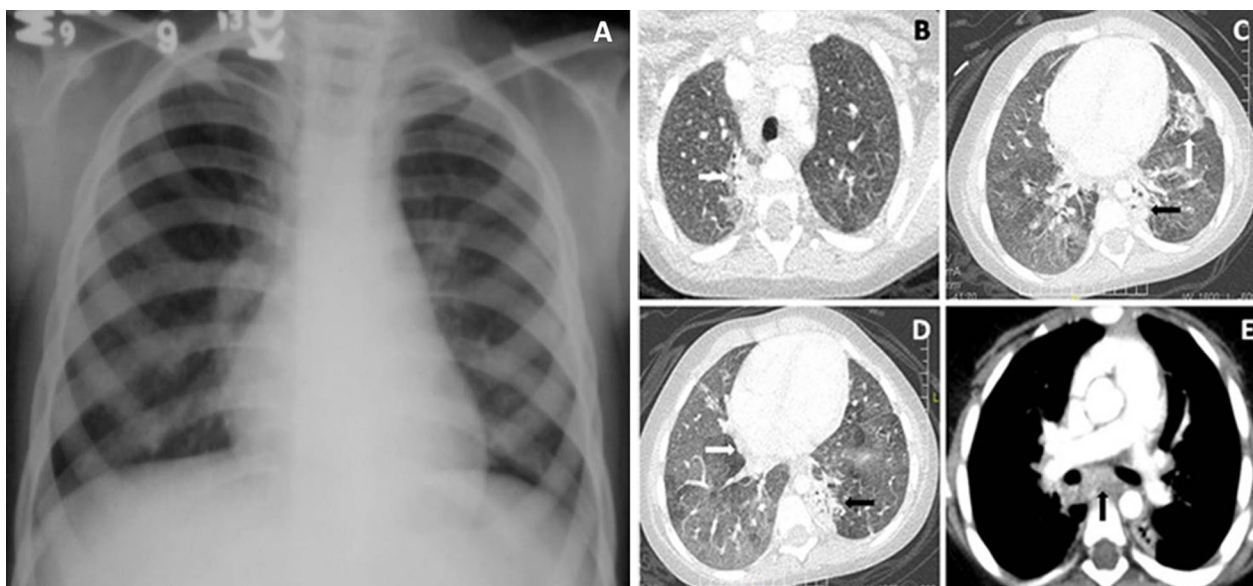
Tubercular Infection. A 13-year-old HIV-positive male presented with fever of 2 weeks' duration. Frontal chest radiograph (A) was normal. CT chest (axial view, lung window) revealed patchy areas of consolidation & ground-glass opacity in bilateral lung parenchyma (arrow in B,C,D). Conglomerate, mildly enhancing mediastinal lymph nodes were noted in subcarinal location (arrow, E) on mediastinal window. Patient's CD4 count was 425 cells/cu.mm. BAL isolated *Mycobacterium*, and Mantoux test was positive. Patient started on ATT on the basis of these findings and showed significant clinical improvement
